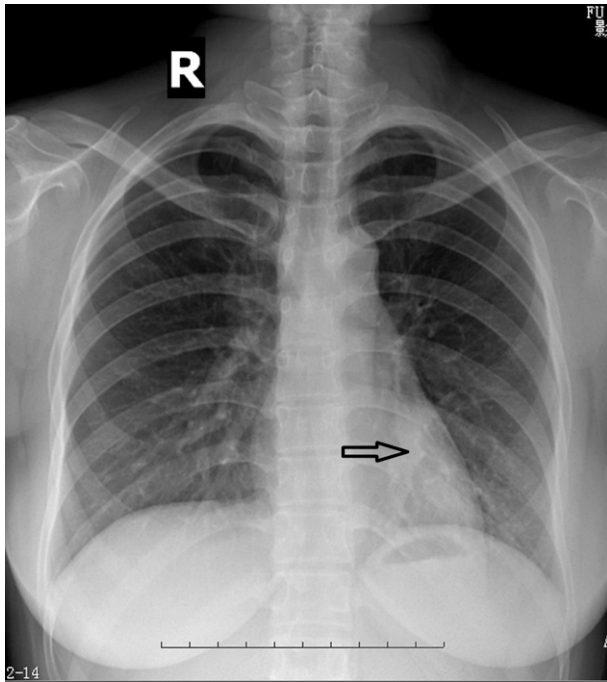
Preoperative chest radiograph shows a smooth and highly dense opacity in the left lower lobe behind the heart (black arrow).
